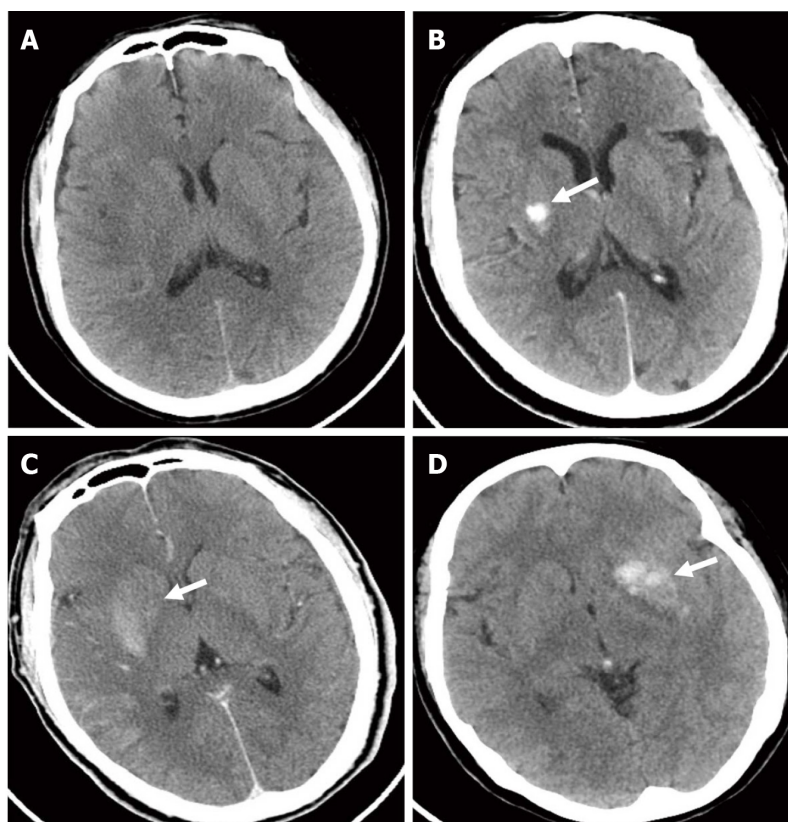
Computed tomography images of non-intracranial high-density areas and high-density areas. A: Computed tomography (CT) image post-endovascular mechanical thrombectomy (EMT) shows no high-density areas (HDAs) in a patient with an admission National Institutes of Health Stroke Scale (NIHSS) of 15 and 3 month modified Rankin Scale (mRS) of 0; B: CT image post-EMT shows right basilar ganglia HDA in a patient with an admission NIHSS of 16 and 3 month mRS of 0; C: CT image post-EMT shows right basilar ganglia and cortical HDAs in a patient with an admission NIHSS of 24 and 3 month mRS of 6; D: CT image post-EMT shows left basilar ganglia HDA in a patient with an admission NIHSS of 25 and 3 month mRS of 6.
